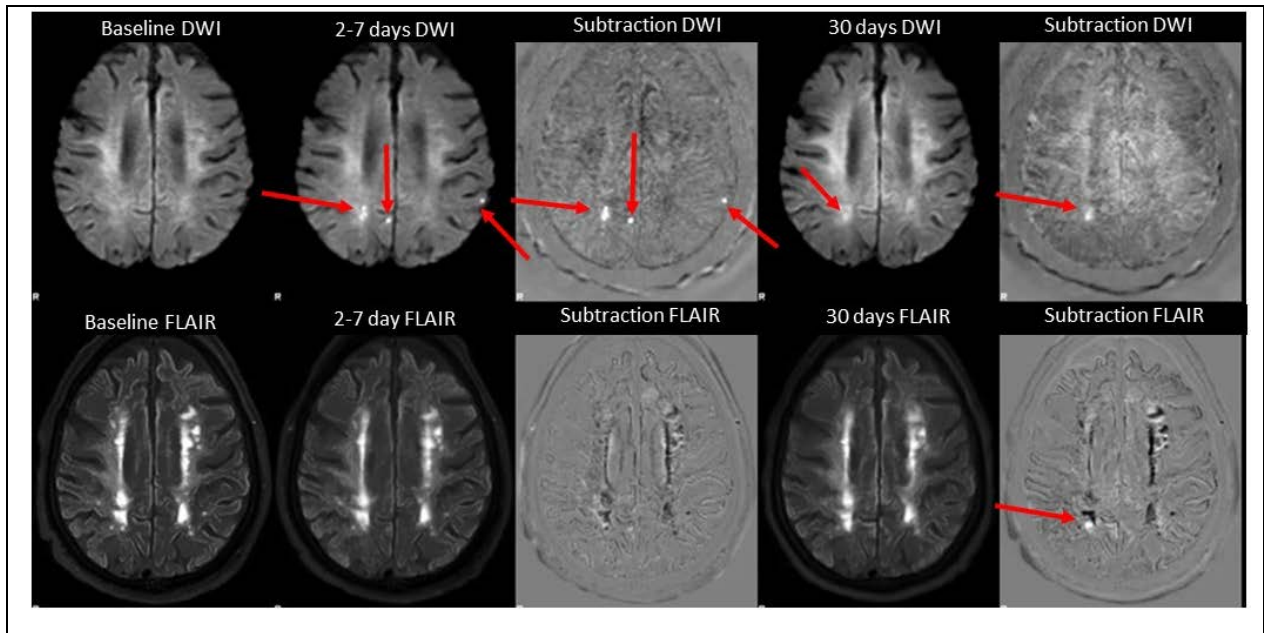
MRI analysis of new DWI lesion volume and number. Lesions were delineated on corrected and aligned DWI and FLAIR images using a semi-automated contouring technique provided by the JIM software package, with simultaneous reference to the subtraction images. Legend: FLAIR-fast attenuated inversion recovery, DWI-diffusion-weighted image.
